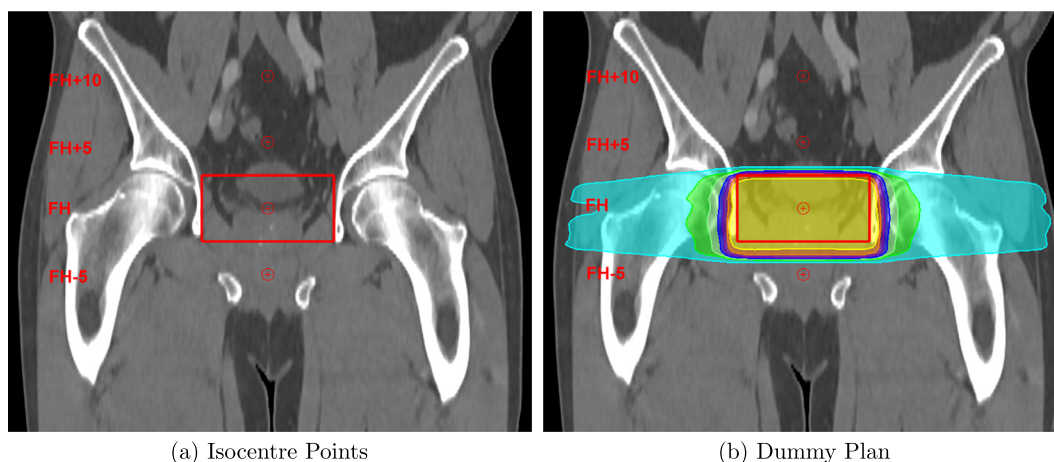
Example CT showing the four isocentre points marking the FH-5, FH, FH + 5 and FH + 10 levels (a) and the cylindrical PTV (red line) and dummy plan dose at the FH level (b).
